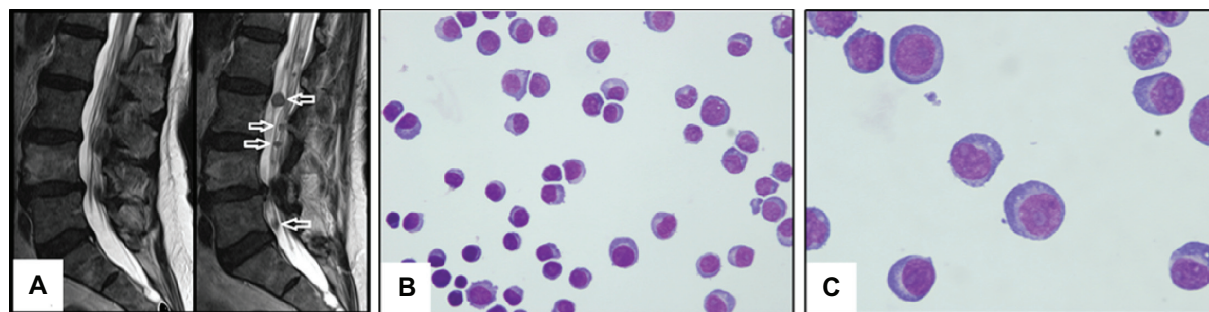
(A) Left: MRI obtained before onset of pain and neurological symptoms demonstrates no intradural lesions. Right: MRI obtained 4 months later and after onset of symptoms began reveals multiple intradural extramedullary lesions. (B) CSF contained numerous plasma cells, several with atypical morphology including plasmablastic features. (C) CSF plasma cells demonstrated plasmablastic morphology.
